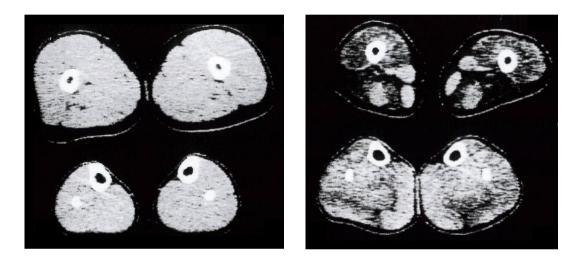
Quadriceps (top) and Calf CT scans of control (left) and DMD individuals. Dark areas of CT indicate areas of less dense adipose infiltrates in muscle tissue. Gross Cross-sectional Area (ASCA) of calves is increased in DMD in presence of reduced muscle mass (Jones et al, 1983).
